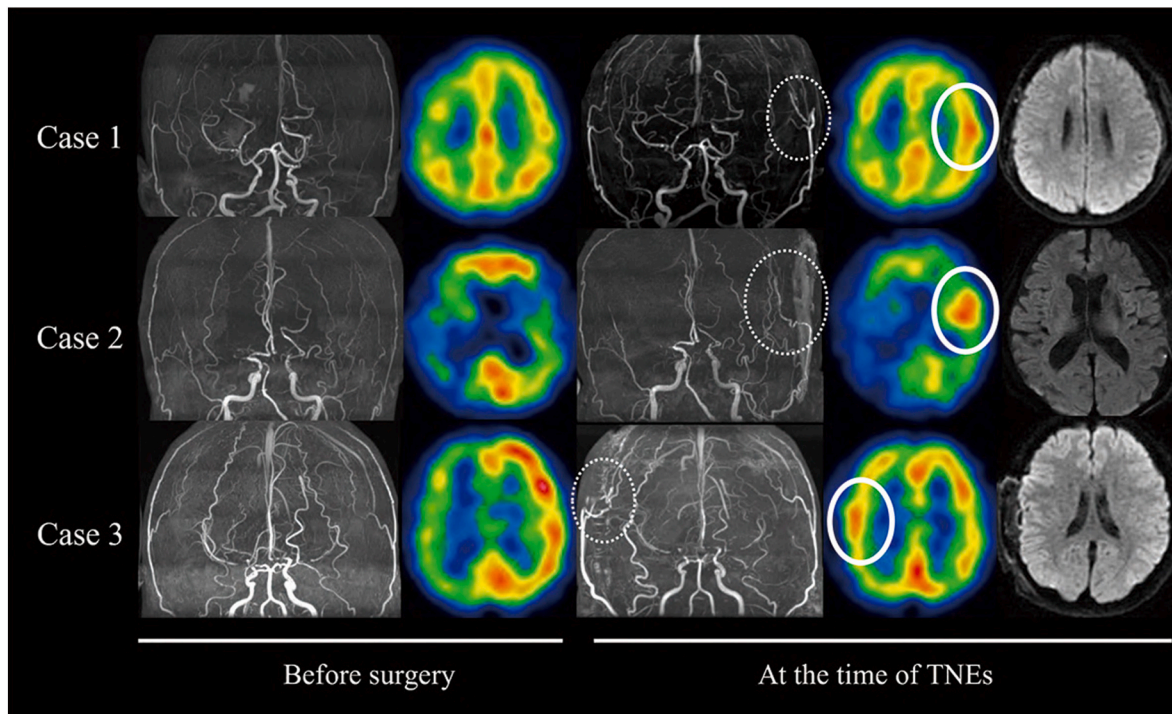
Images of the three cases resulting in TNEs. The top row shows Case 1, the middle row shows Case 2, and the bottom row shows Case 3. The same slices of pre- and postoperative SPECTs and diffusion-weighted MR images are shown.
